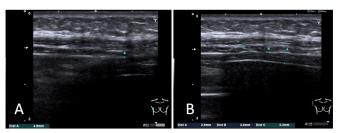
Diaphragm ultrasonography reveals that right diaphragm contracts normally (thickness of diaphragm [tdi]; Figure 1A: tdi at end-inspiration, 4.9 mm; Figure 1B: tdi at end-expiration, 2.6 mm; Atdi% of 88.4%).
